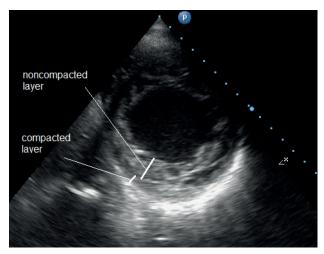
Patient 32 y.o. Echocardiography. Short axis view. Ratio of non-compacted to compacted layers 2,6:1.
